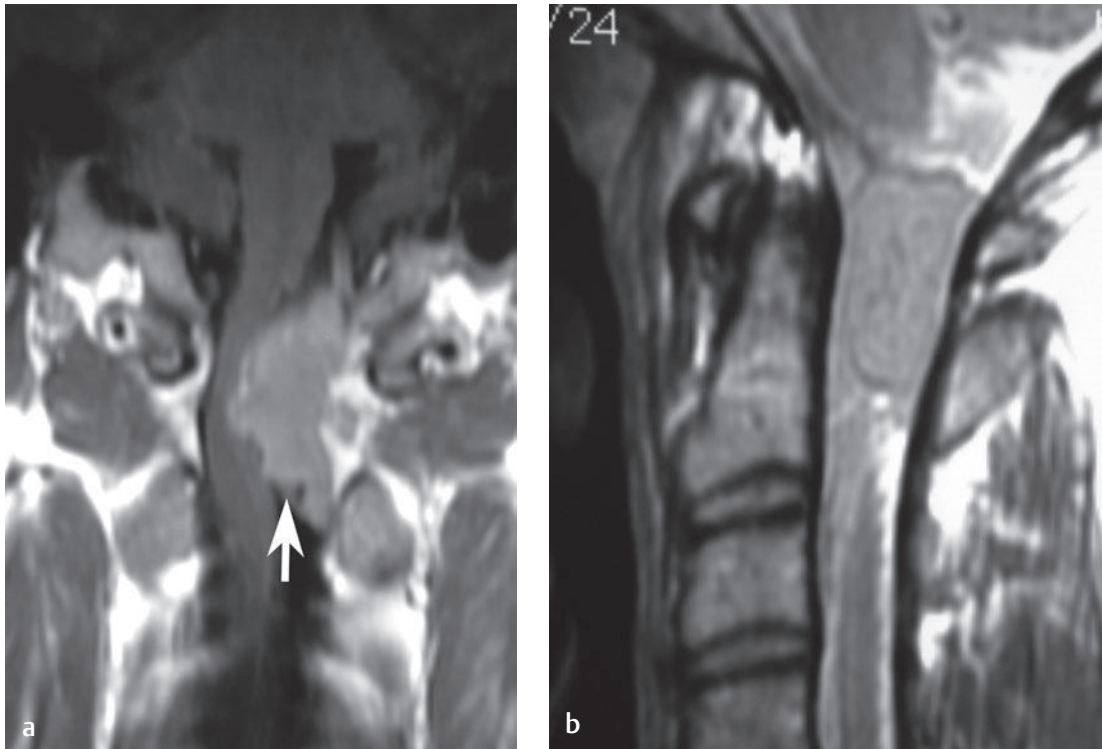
Cervical meningioma. (a) A coronal postgadolinium T1-weighted image shows a widely dural-based lesion (*arrow*) that enhances and is hyperintense compared with the spinal cord. (b) On a sagittal T2-weighted image, the lesion is slightly hyperintense compared with the spinal cord, showing cord displacement and widening of the ipsilateral CSF space, characteristic of intradural–extramedullary lesions.[†]
